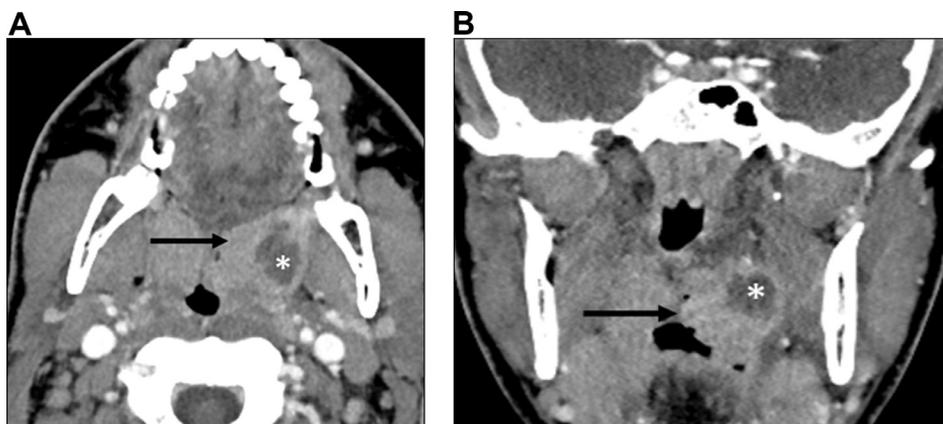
Peritonsillar abscess: 23-year-old female presenting with fever and sore throat. Contrast enhanced CT neck reveals enlarged bilateral palatine tonsils with striated enhancement consistent with acute tonsillitis. There is a peripherally enhancing hypodense fluid collection in the left parapharyngeal space (*) consistent with a peritonsillar abscess. The abscess is causing inferomedial displacement of the left palatine tonsil (black arrows).
